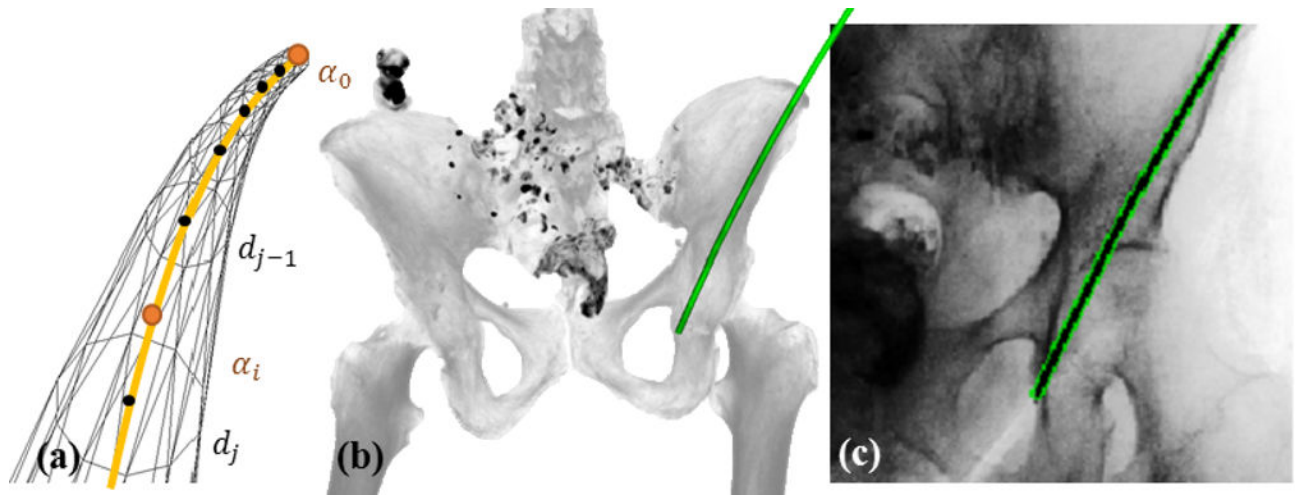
(a) B-spline control points and disc-based mesh tessellation. (b) Maximum intensity projection of the pre-operative CT with registered components for trajectory position c. (c) Projection of deformable known-component overlaid on radiograph.
